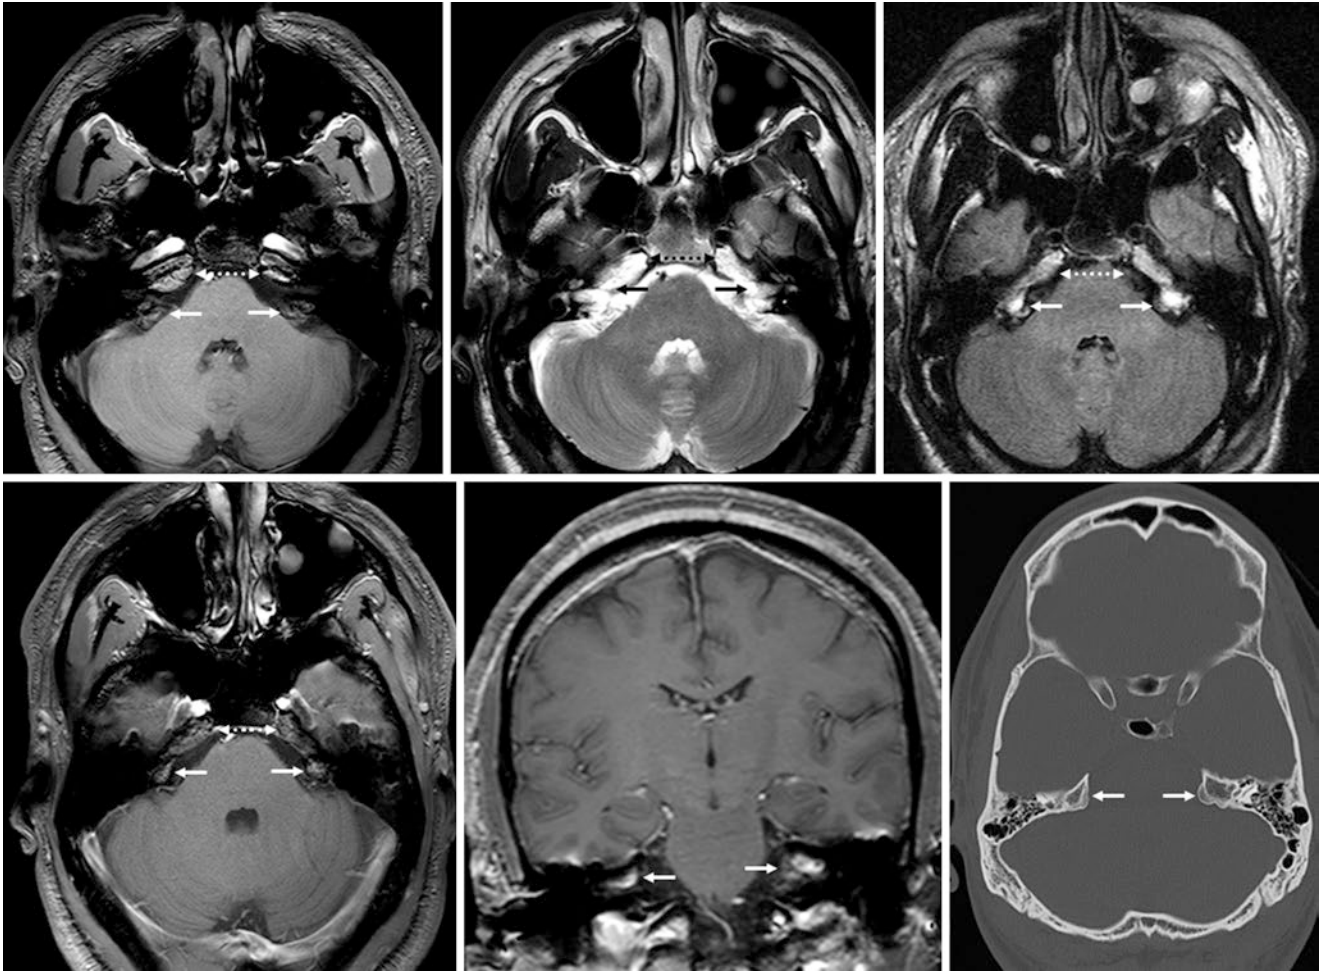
A 31 year old was evaluated for recurrent metastatic disease after a frontal craniotomy (*note dural enhancement, bottom right*) hyperintense signal within the petrous apices bilaterally on all MR sequences (*arrows*), including T1WI (*top left*), T2WI (*top middle*), FLAIR (*top right*), and on postcontrast axial (*bottom left*) and coronal
